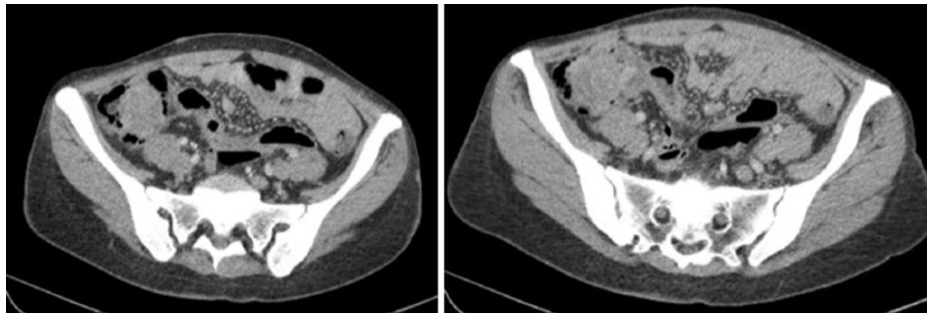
Contrast-enhanced abdominal CT scan showing cecal thickening.
